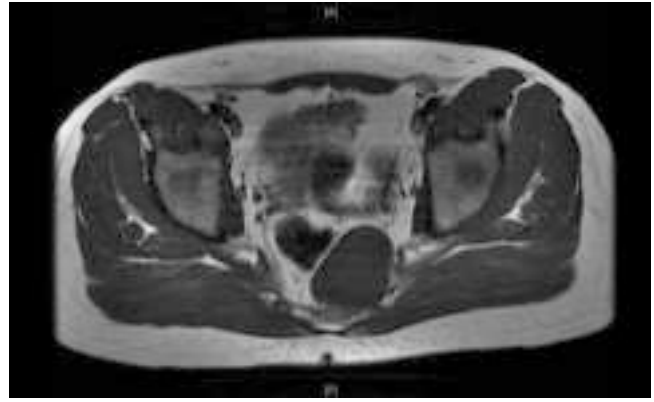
MRI image of a ganglioneuroblastoma.
